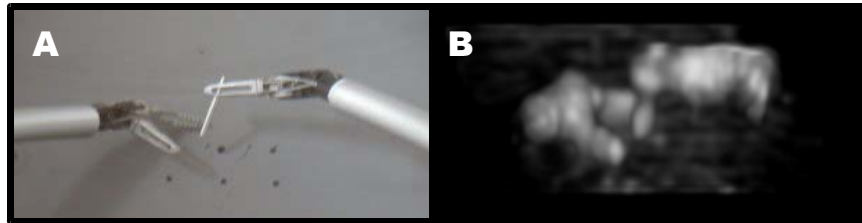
(A) Image of passing object from one grasper to the other. (B) Corresponding 3D ultrasound image.
